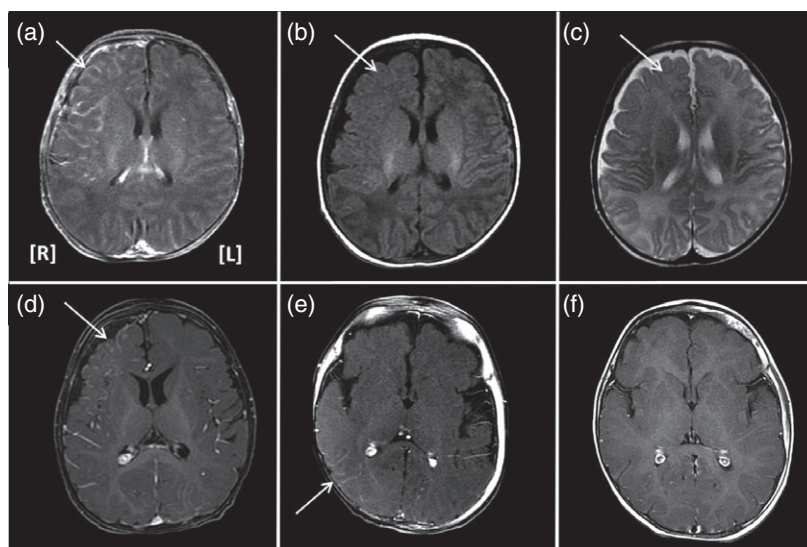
(a–c) Patient 1 aged 1 month with a right facial port-wine birthmark (PWB). (a) Postgadolinium axial T1-weighted image with fat saturation shows a right leptomeningeal enhancement (arrow). (b) On the same area, axial T1-weighted image shows hypersignal of the white matter (arrow) and (c) hyposignal of the white matter on axial T2-weighted image (arrow). (d) The same patient aged 9 months, enhancement of right leptomeningeal angioma confirms the diagnosis of Sturge–Weber syndrome (SWS) on post gadolinium axial T1-weighted image (arrow). (e,f) Patient 2 aged 3 months with a right facial PWB. (e) Suspicion of posterior right leptomeningeal enhancement on axial postgadolinium T1-weighted image (arrow). (f) At the age of 13 months, MRI ruled out the diagnosis of SWS with no visible leptomeningeal enhancement after gadolinium. This patient was asymptomatic at 10 years.
